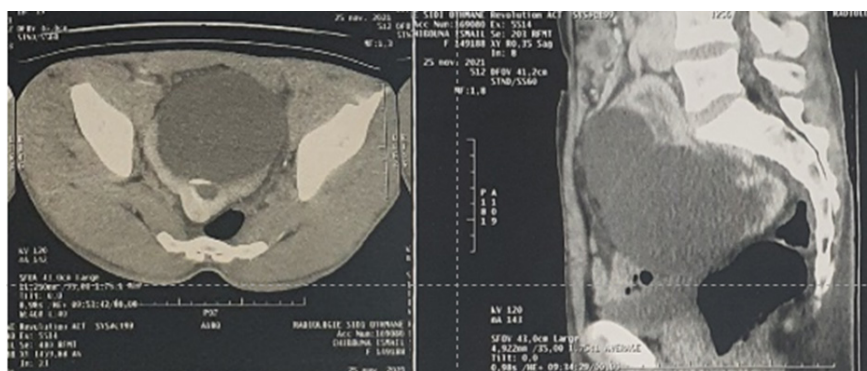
URO-CT showing a syndrome of the pyelo-ureteral junction on an ectopic right kidney in the pelvic position.
